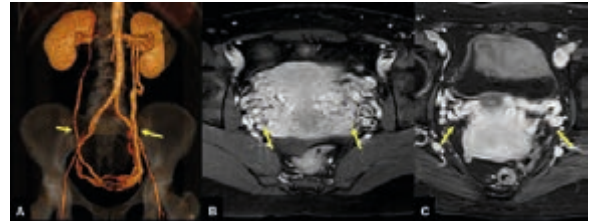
Pelvic congestion syndrome. A) 3D reconstruction, abdominal and pelvic coronary computed tomography angiography (CCTA), reflux of contrast material towards the left gonadal vein crossing the midline through the periuterine venous plexus until reaching the right gonadal vein. B) and C) Two examples of periuterine venous plexus dilatation.
